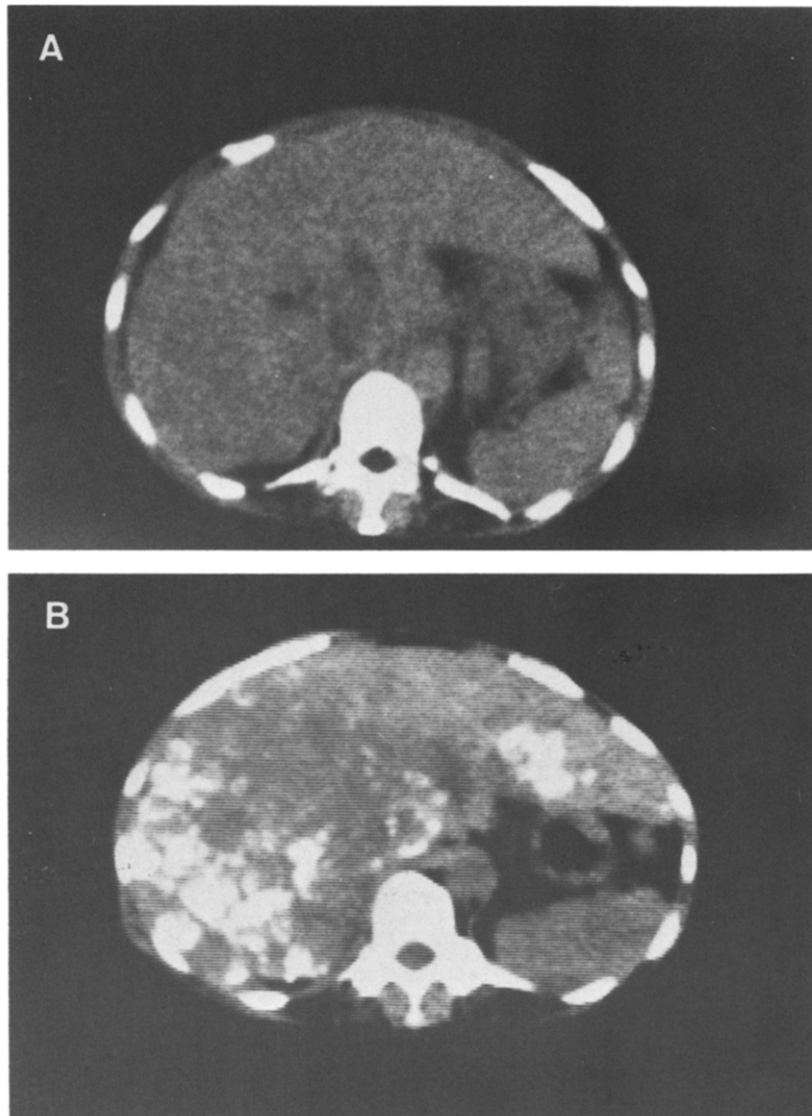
Computerized tomogram (CT) of a 48-yr-old with unresectable hepatoma (case 2). (A) Before administration of SMANCS-ethiodol; (B) 1 week after administration of SMANCS-ethiodol. The tumorous area became clearly visible as a white high density area.
